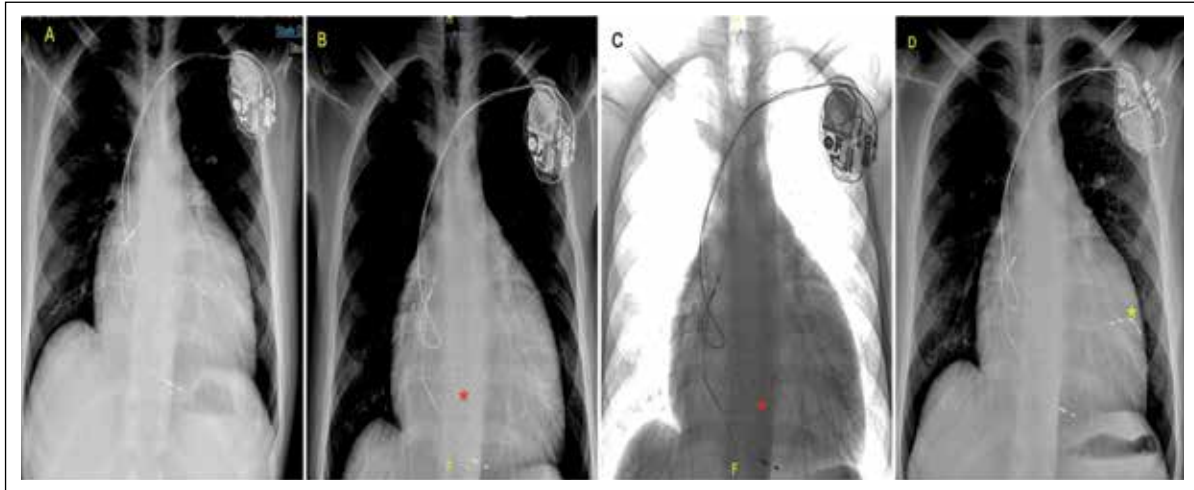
CRT-P (A) presented with heart failure, noted to have LV lead non-capture on follow-up. X-ray showed likely displaced LV lead (red *) (B), which was unclear in routine exposure. When the exposure was decreased, the lead position could be confirmed to be in the proximal coronary sinus. For better visualisation, inversion of the x-ray film can clearly show the lead position (C). Subsequently, he underwent LV lead repositioning. The Frontal chest radiograph showed the final position of the LV lead (yellow *) (D).
